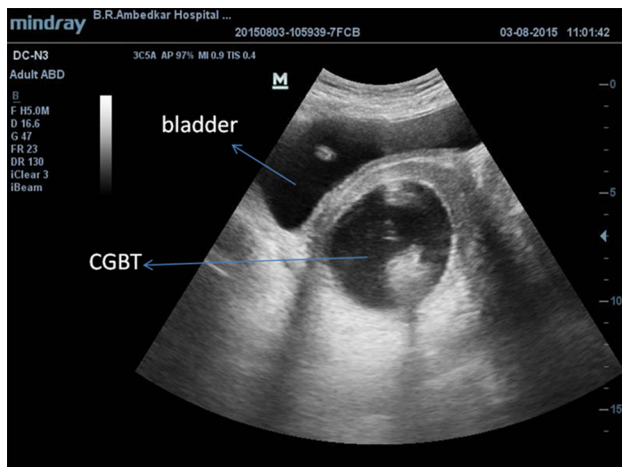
Ultrasonography showing CG Balloon used as tamponade in a case of partial thickness anterior cervical laceration
